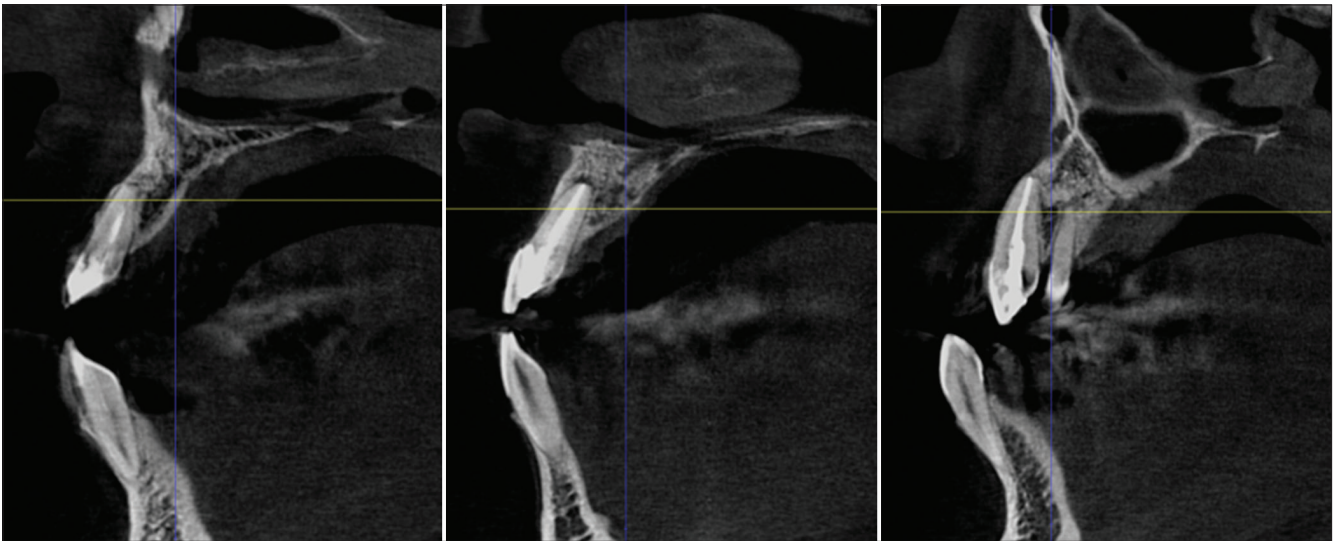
5-year follow-up sagittal view CBCT
